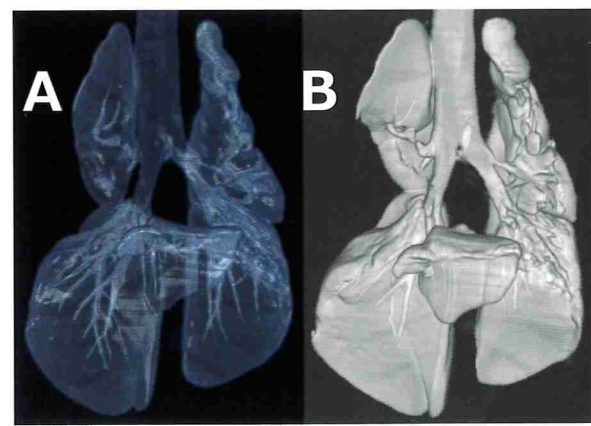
B 3D-CT examination (A, B). The lung lobes other than the right middle lung lobe expanded (A). Bronchi of the right cranial lung lobe and the left cranial lung lobe severely collapsed (B).
